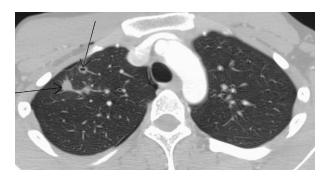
CT scan of lungs before pneumothorax surgery, showing right-sided pneumothorax and small cavitary lesions (arrows).
